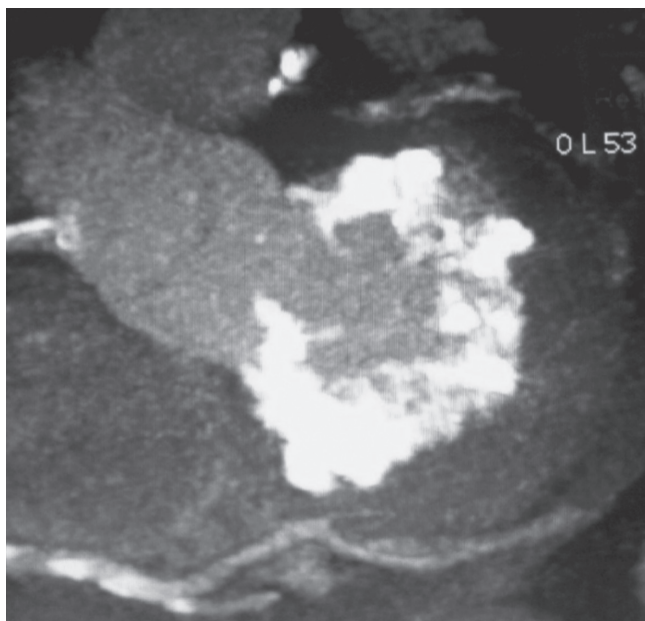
Mitral annular calcification on CT. Courtesy of M. Urena-Alcazar.
